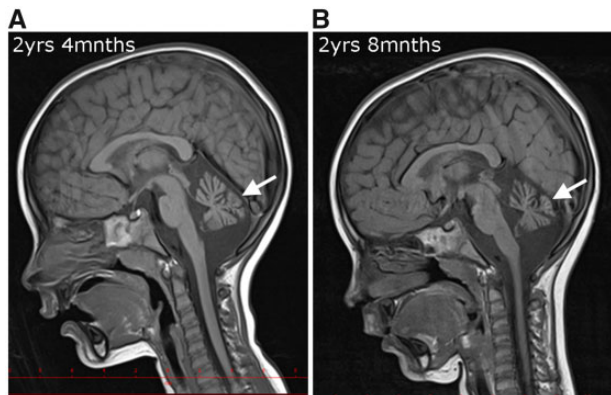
Brain MRI. Brain MRIs show progressive cerebellar atrophy (white arrows) in the patient at (A) 2 years and 4 months; (B) 2 years and 8 months.
